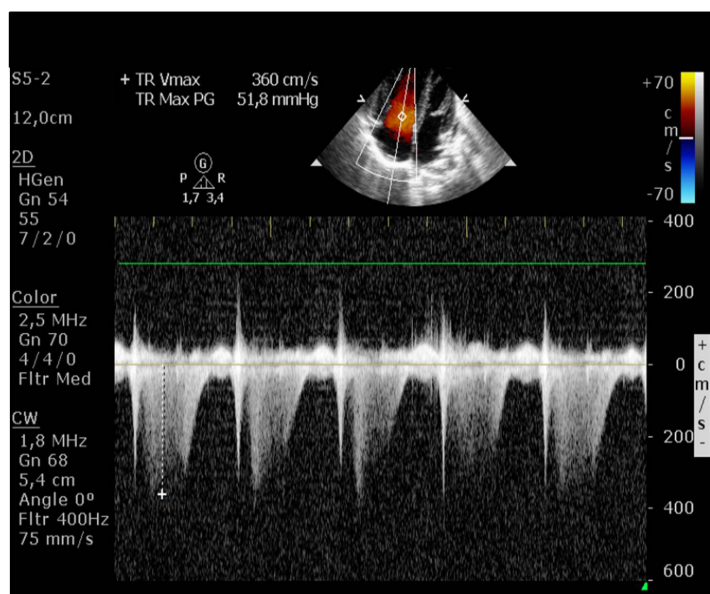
Transthoracic echocardiogram showed tricuspid regurgitation (Vmax 3.6 m/s, TVG 51 mmHg)
